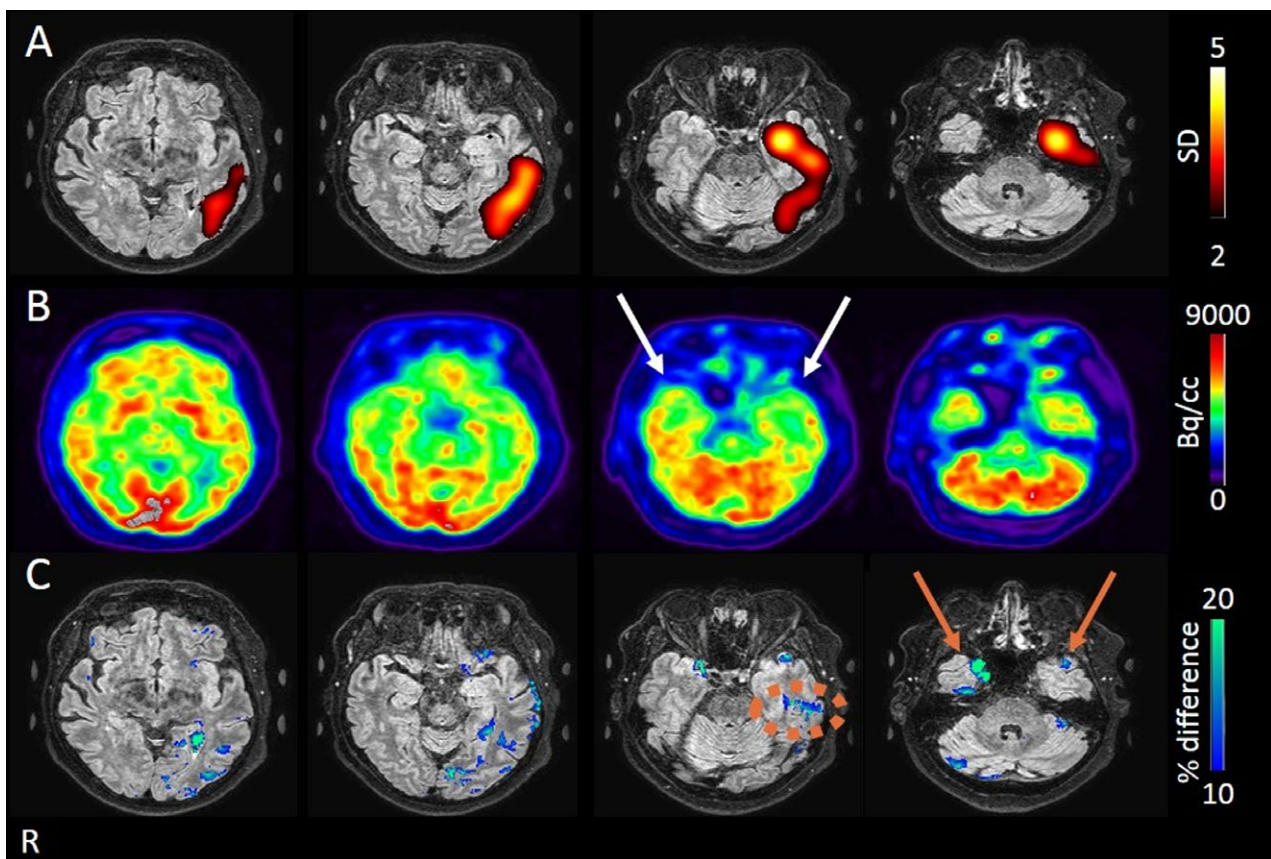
A, SISCOM images showing ictal hyperperfusion in the left temporal lobe. SISCOM images were expressed as z-scores on transversal MRI slices showing areas of hyperperfusion (yellow-red) thresholded between 2 and 4 standard deviations (SDs). B, FDG-PET showed bitemporal hypometabolism (white arrows). C, ACAI analysis of the PET image in B confirmed the bitemporal hypometabolism (with left-right asymmetries in both temporal poles, orange arrows) and revealed a more extensive hypometabolism in the left temporal lobe (orange circle). Slices are shown in the radiologic convention
